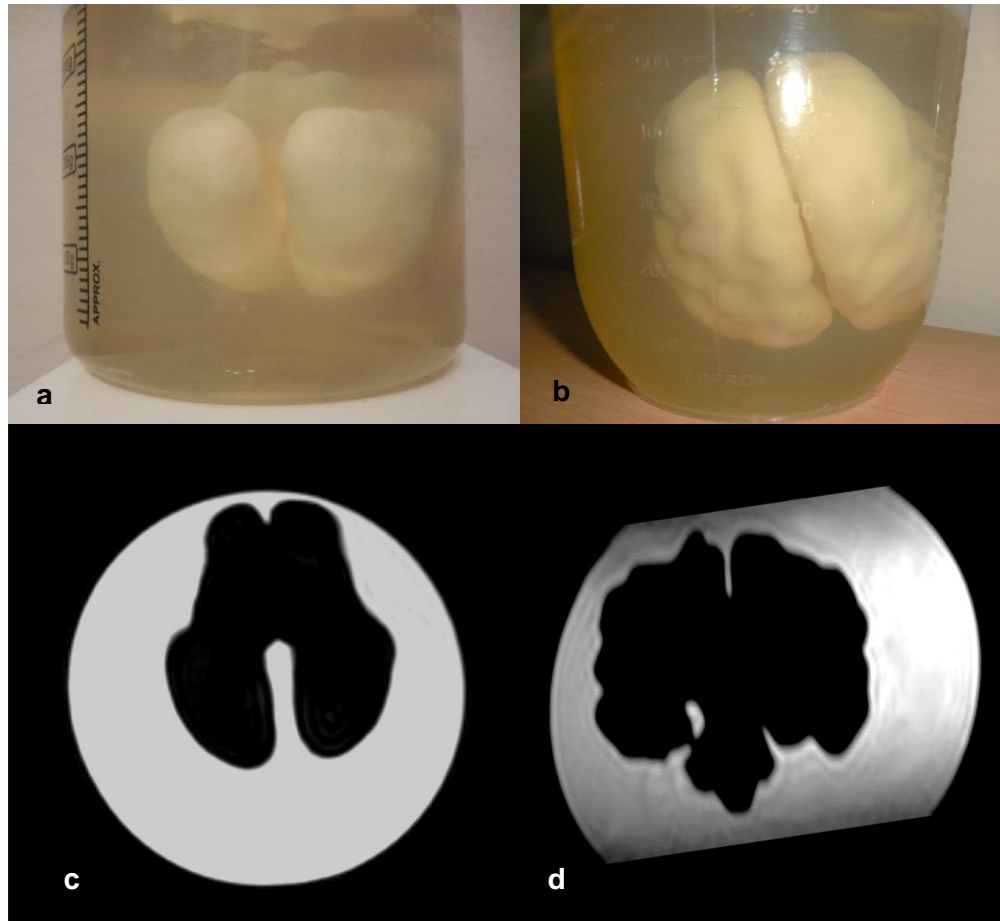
23 weeks gestation brain model suspended in gelatin (a) and resultant MR image (c) and equivalent images (b and d) for the 30 week brain model
